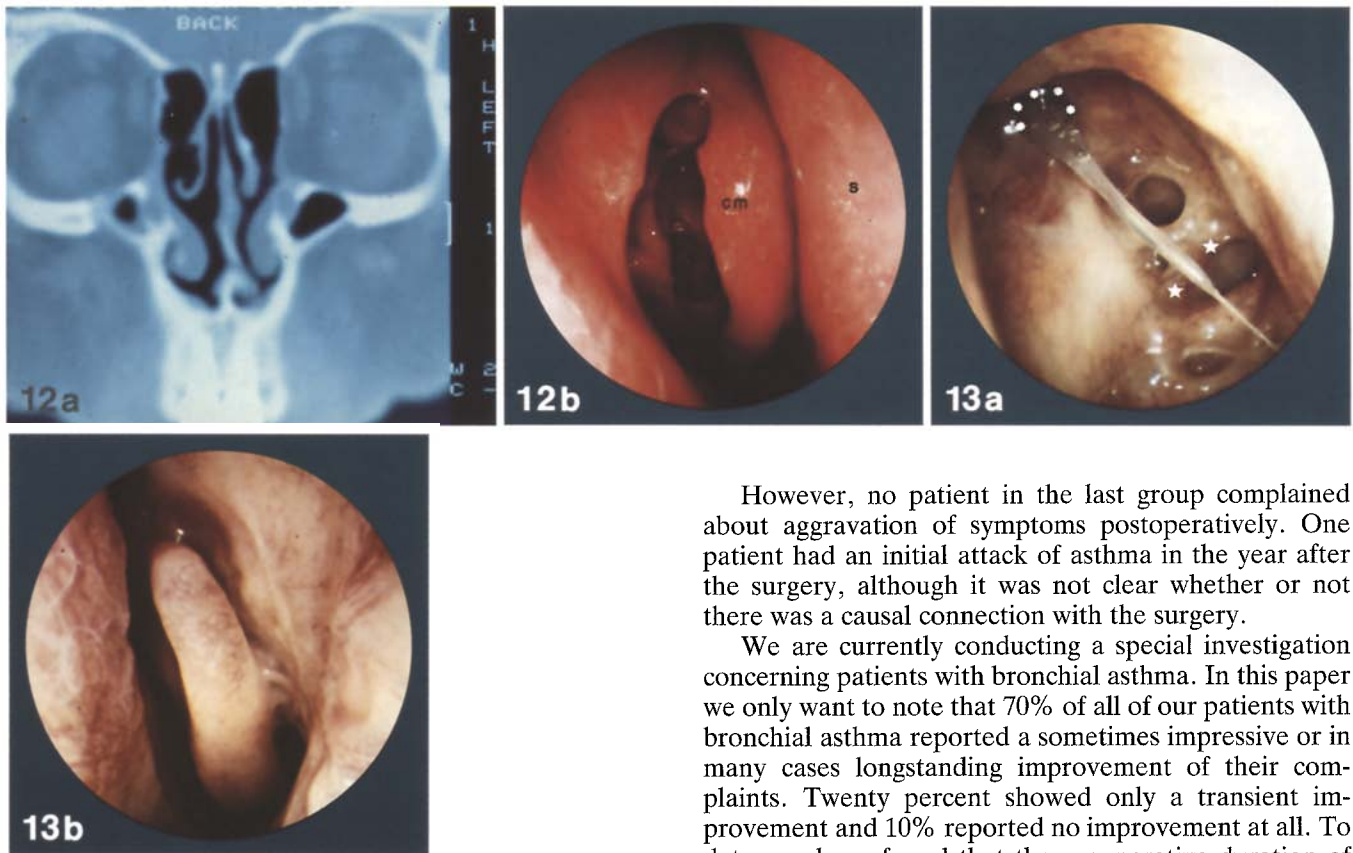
a CT scan of normalized ethmoid area after functional endoscopic surgery. b Endoscopic view of the middle meatus after endoscopic surgery (for diseased concha bullosa and anterior ethmoid.) The mucosa has normalized without the entire ethmoid having been exenterated. The medial lamella of the concha bullosa was not sacrificed to provide a normal middle turbinate
